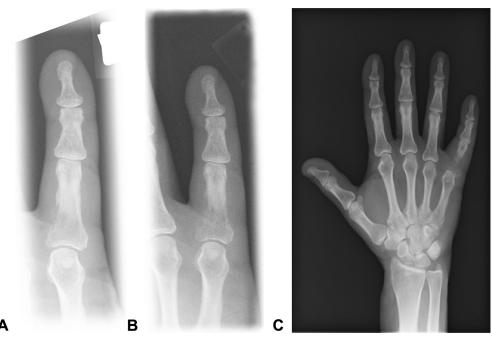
A Radiography demonstrates an osteolysis and a pathological fracture of the right little finger. B Radiography demonstrates an osteolysis and a pathological fracture of the right little finger. C Radiography demonstrates an osteolysis and a pathological fracture of the right little finger.
